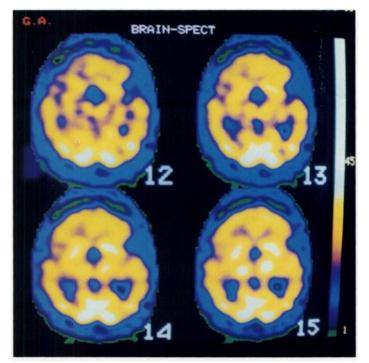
SPECT ^{99m}Tc-HMPAO brain image demonstrates perfusion defect in the opercular area and posterior frontal area in the left lobe.
